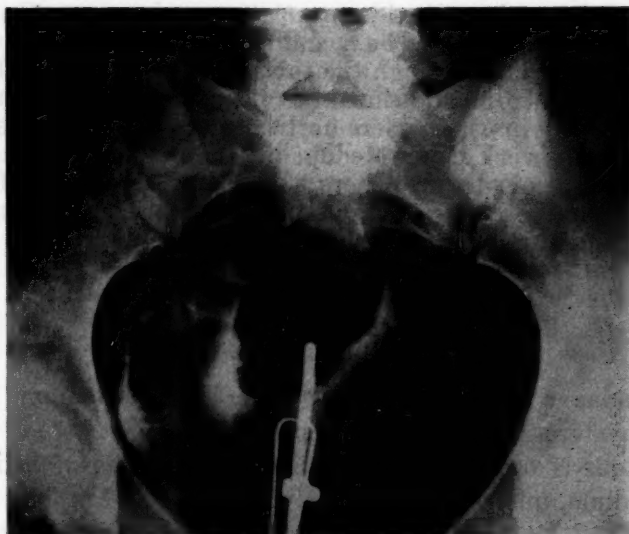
X-ray plate of the pelvis after insufflation of carbon dioxide for 2 minutes under sustained pressure of 200 mm. Hg. Note that the medium has left the uterine cavity and has been distributed in the pelvic cavity.
